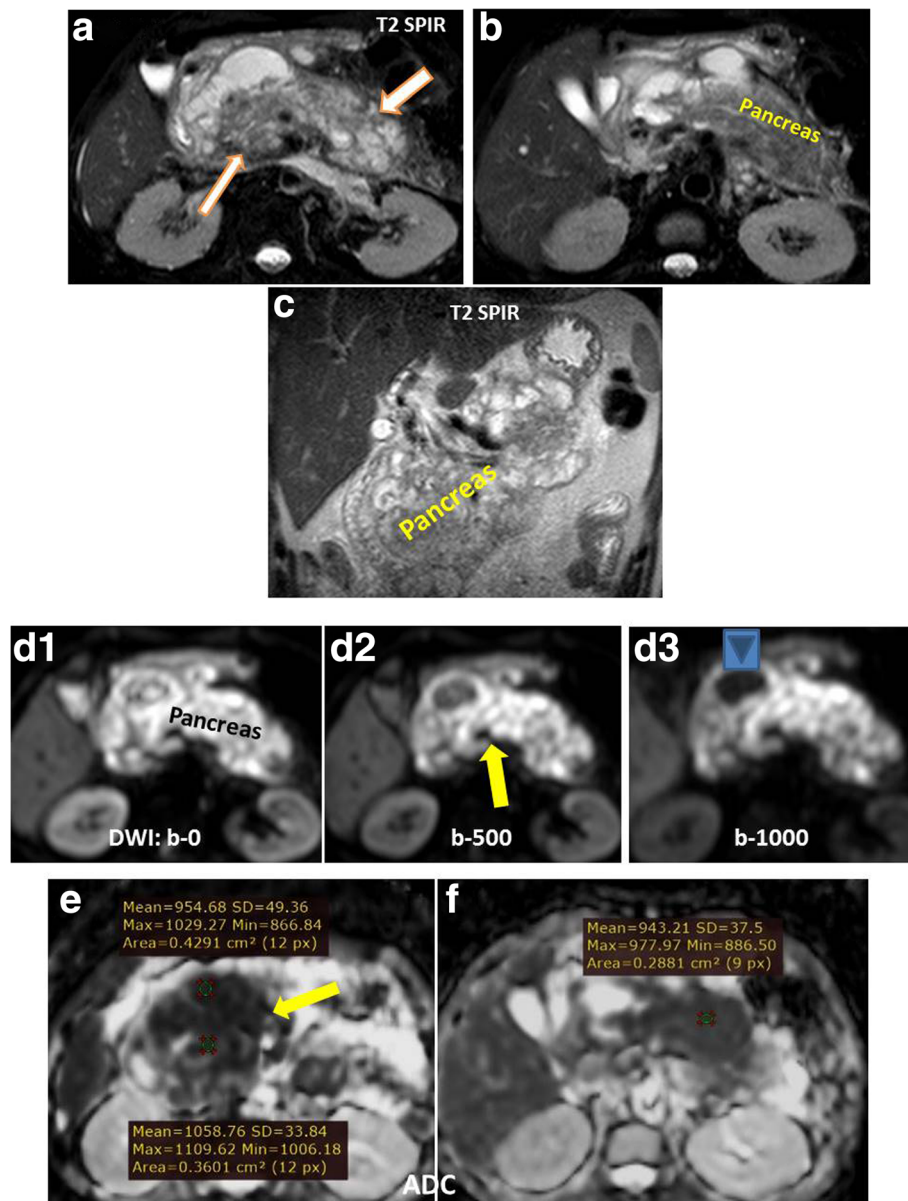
A 55-year-old male patient comes by epigastric pain and discomfort. a–c Axial and coronal T2 fat saturation sequence showed diffusely enlarged swollen pancreas (head, body, and tail) with heterogeneous signals and relatively preserved peri-pancreatic fat planes. The pancreatic vessels are totally encased inside the lesion. d1–d3 DWI at multiple b values (0, 500, and 1000 s/mm^2) demonstrates the increase of degree of lesion restriction by the increased b value denoting the malignant nature of the lesion apart from the facilitated cystic degenerated part of the lesion in which the signal was progressively reduced (colored arrow head). e, f ADC map of the pancreas showed low signal of the lesion and the measured ROI reflected the low ADC value ($0.9\text{--}1.0 \times 10^{-3} mm^2/s$). Also, the mesenteric vessels are noted near totally encased within the lesion (yellow arrow at d2 and e) (non-resectable lesion)
